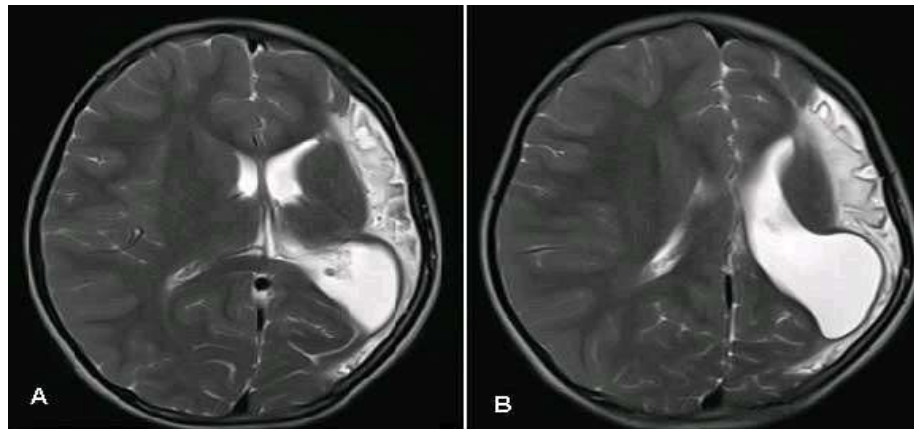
MRI T2W axial images show left cerebral hemiatrophy, dilatation of ipsilateral lateral ventricle and ipsilateral mid line shift of 7 mm
